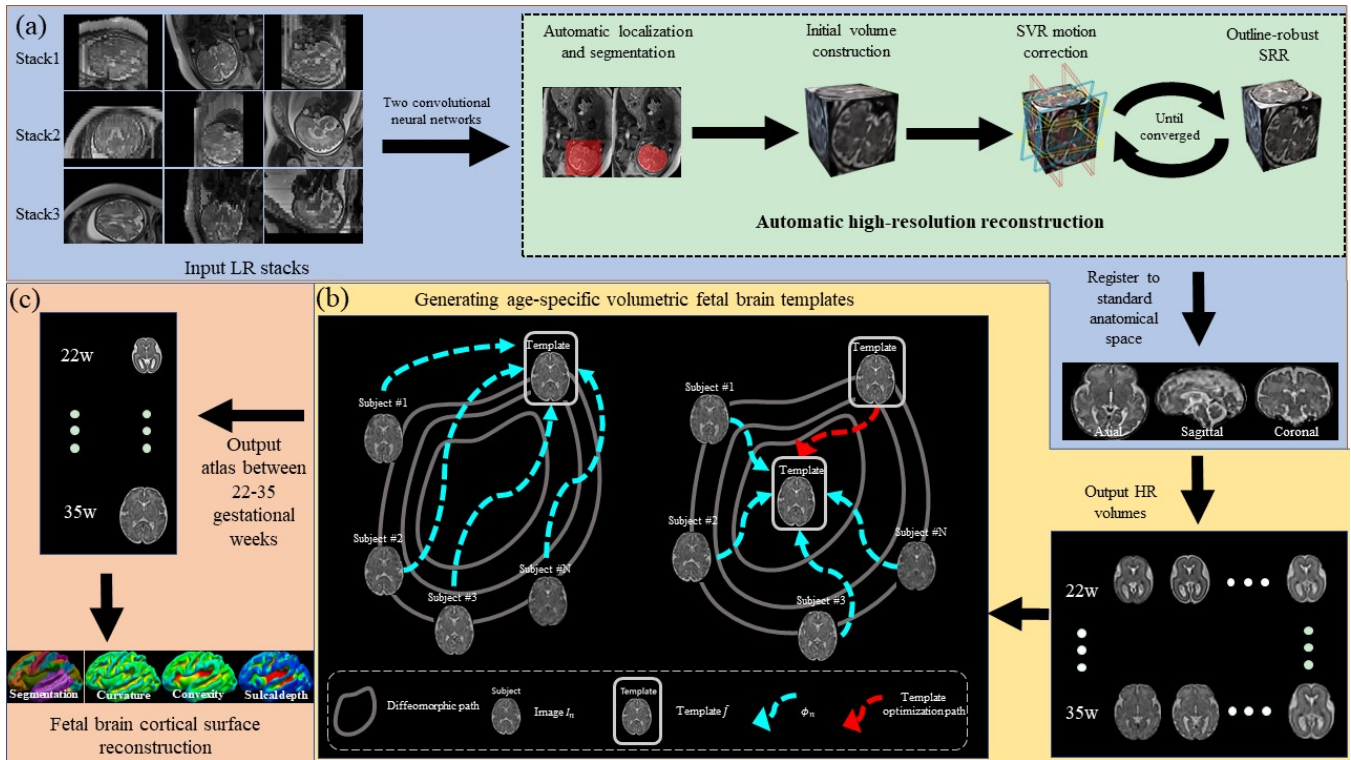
(a) The framework for 3D individual fetal brain MR image reconstruction including brain extraction, high-resolution (HR) volume reconstruction in standard anatomical space, and cortical surface reconstruction; (b) The overview of the two-step optimization atlas construction strategy. Firstly, referring to the current template space \bar{J} , the diffeomorphic transforms ϕ_n between the subject volumes I_n and the template \bar{J} are estimated. Then the template \bar{J} is updated by optimizing the distance in a diffeomorphic path with ϕ_n ; (c) cortical surface reconstruction.
